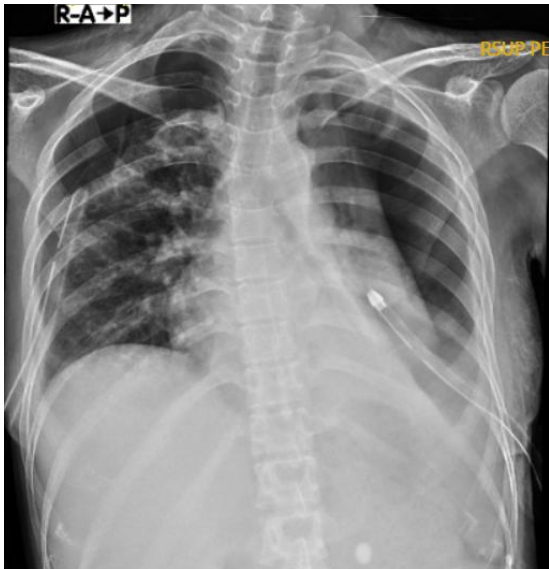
Thoracic x-ray on November 26, 2023
